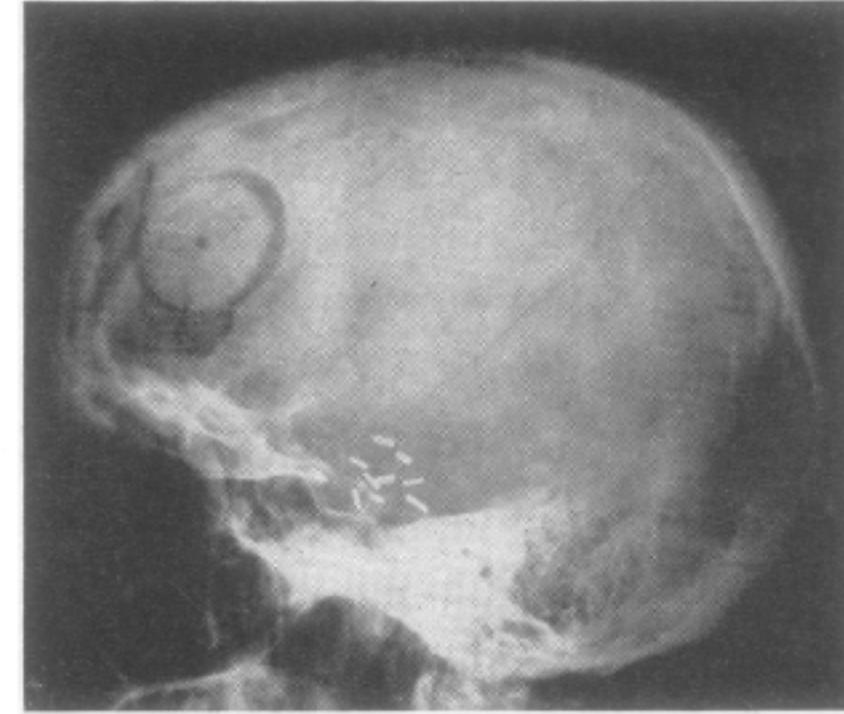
Post-operative skull radiograph with silver clip markers outlining extent of bilateral resections limited to the uncus and amygdala.
